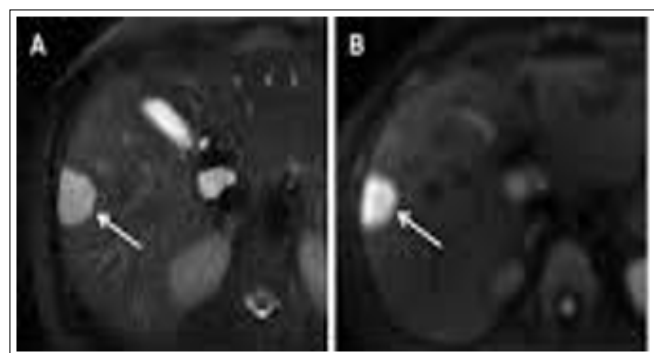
Light-bulb sign on MRI
